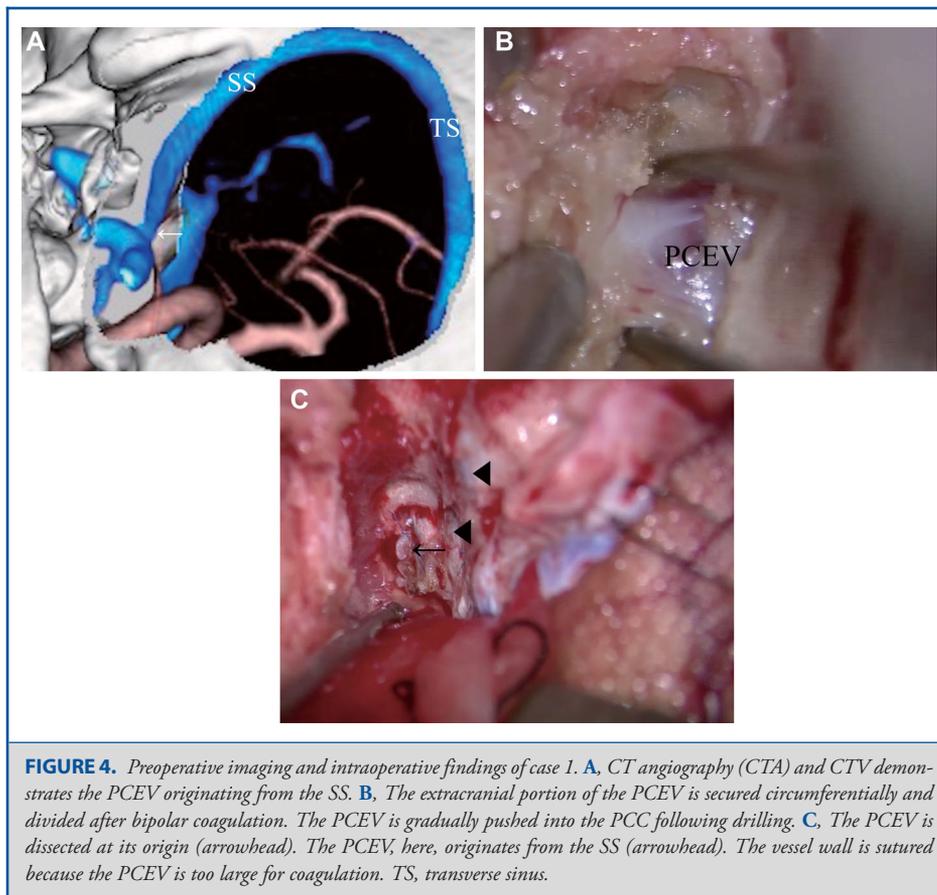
Preoperative imaging and intraoperative findings of case 1. A, CT angiography (CTA) and CTV demonstrates the PCEV originating from the SS. B, The extracranial portion of the PCEV is secured circumferentially and divided after bipolar coagulation. The PCEV is gradually pushed into the PCC following drilling. C, The PCEV is dissected at its origin (arrowhead). The PCEV, here, originates from the SS (arrowhead). The vessel wall is sutured because the PCEV is too large for coagulation. TS, transverse sinus.
